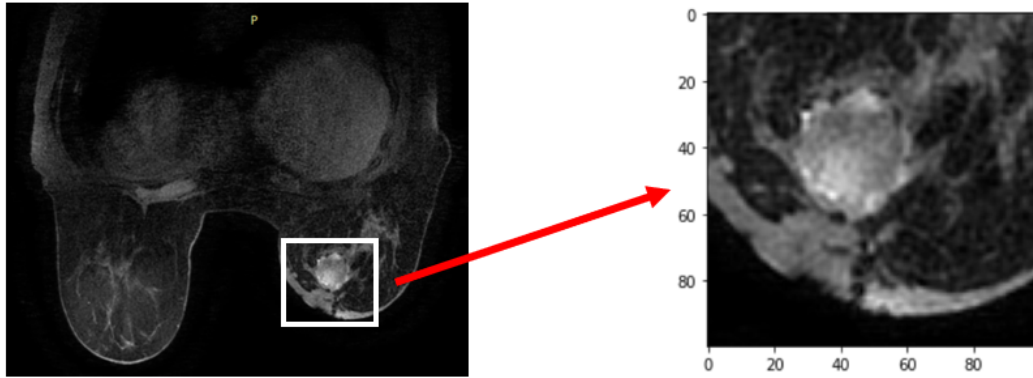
Crop 100x100 in MRI from a patient.
